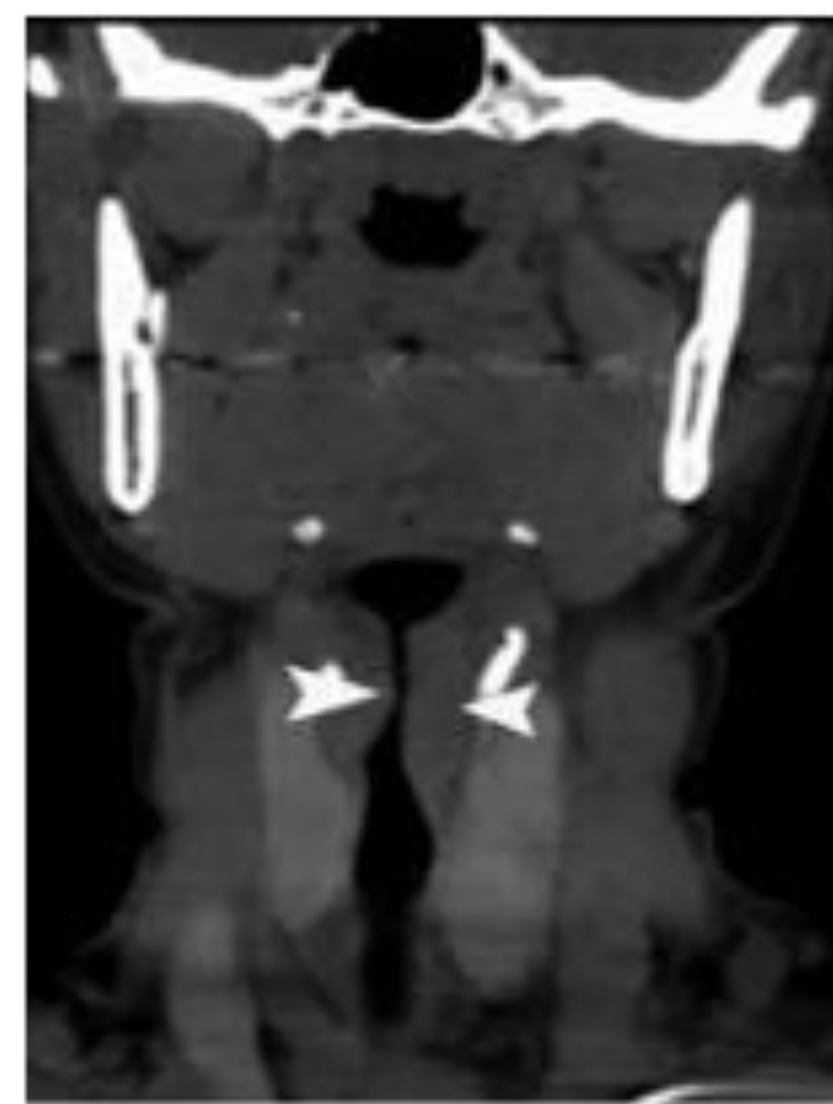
X-ray of human upper airway.
